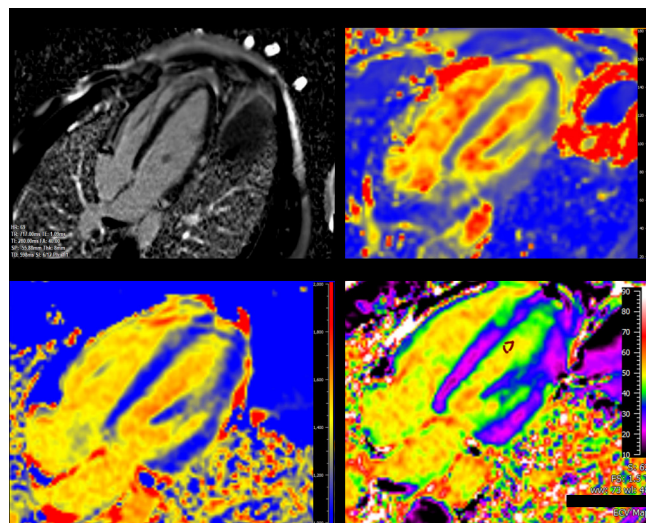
Cardiac magnetic resonance imaging. (A) Four-chamber phase-sensitive inversion recovery image. Ten-minute post-gadolinium showing uptake in the lateral and septal walls. (B) Four-chamber T1 map (ShMOLLI) showing increased T1 time in the mid-lateral and septal walls, corresponding to areas of late gadolinium enhancement (LGE) (normal <1050 ms). (C) Four-chamber T2 map showing oedema in the mid-lateral and septal walls, corresponding to areas of LGE and elevated T1 time (normal <55 ms). (D) Extracellular volume (ECV) mapping showing increased ECV in the affected areas (normal <28%).
